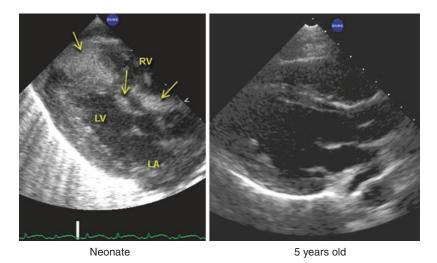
The most common tumor in children is a rhabdomyoma. These are invariably multiple and tend to regress in size over time. The left panel shows a parasternal long axis from a neonate that shows multiple tumors within the interventricular septum (arrows). Multiple
